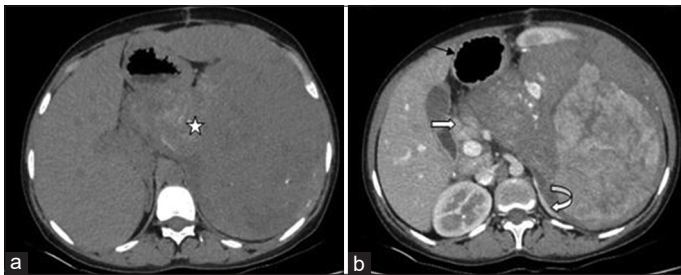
Non-contrast CT (a) and contrast-enhanced CT abdomen axial image (b) showing large heterogeneously enhancing soft-tissue density lesion in the spleen with amorphous cloud like calcification (star) within and lesion is displacing stomach anteriorly and to right (black arrow), pancreas posteroinferiorly (white arrow) and to right and left adrenal medially (curved arrow)
